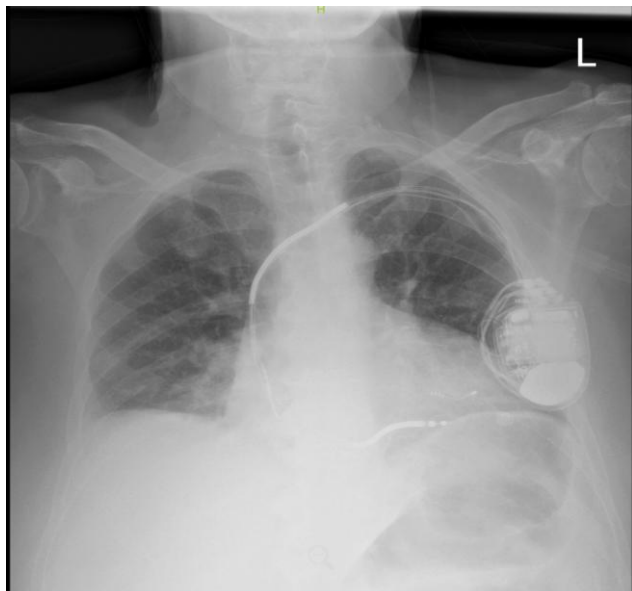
Chest Radiograph Demonstrating Bilateral Airspace Opacities. Portable AP chest radiograph demonstrating low lung volumes with bilateral, patchy airspace opacities in the mid-to-lower lung zones. A left-sided cardiac device with transvenous leads is present. Findings are suggestive of non-cardiogenic pulmonary edema in the appropriate clinical context.
